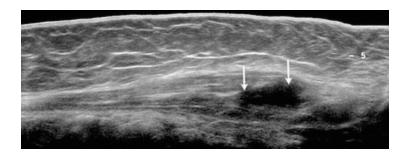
Longitudinal ultrasound image with extended field-of-view shows anechoic hematoma (arrows) within rectus abdominis muscle following indirect trauma in a professional tennis player
